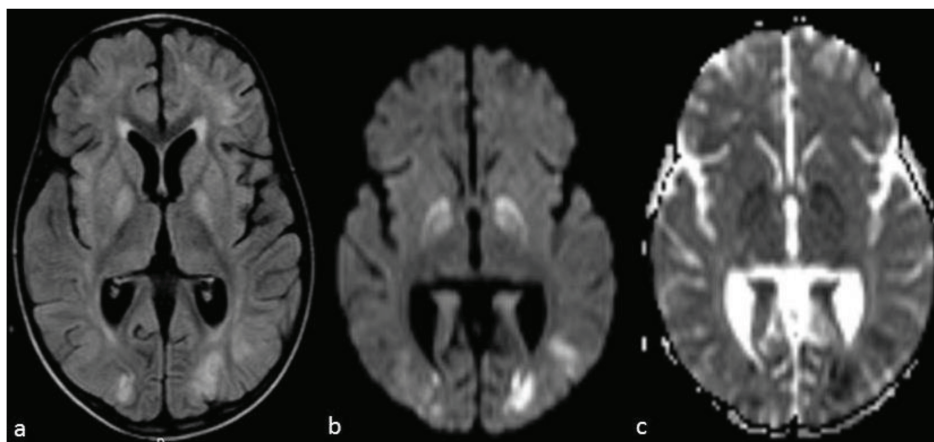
4-year old boy after liver transplantation (patient 1). Axial MR image a. (fluid attenuation inversion recovery) demonstrates involvement of bilateral globus pallidi and frontal and occipital lobes. Diffusion-weighted images b. with b-1000 and c. with apparent diffusion coefficient demonstrate decreased diffusion in the occipital lobes and globus pallidus.
